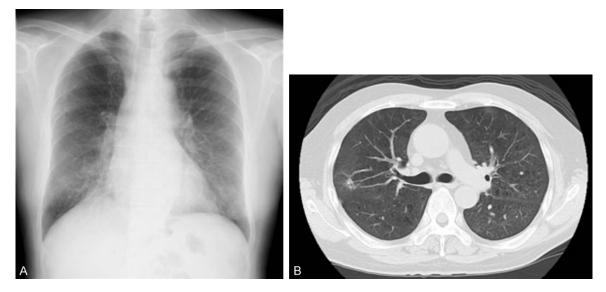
Chest images of MTX pneumonia. A. Radiograph: ground-glass opacities seen in the right middle lobe; B. CT: ground-glass opacities seen in the right middle lobe.
